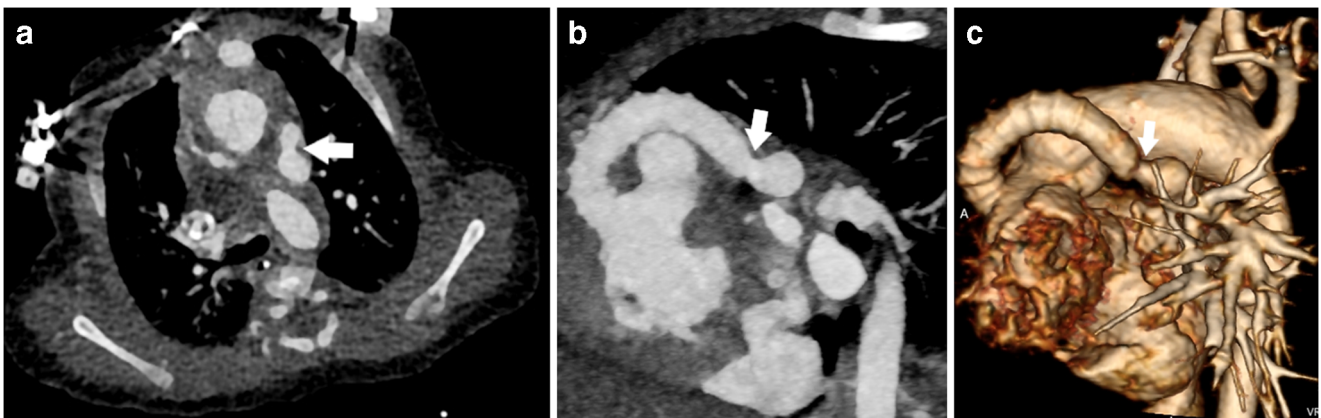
A 7-week-old girl with Sano shunt stenosis. a–c Axial (a), sagittal (b) and three-dimensional rendered (c) cardiac CT angiography images show patent Sano shunt with moderate focal stenosis at its distal
